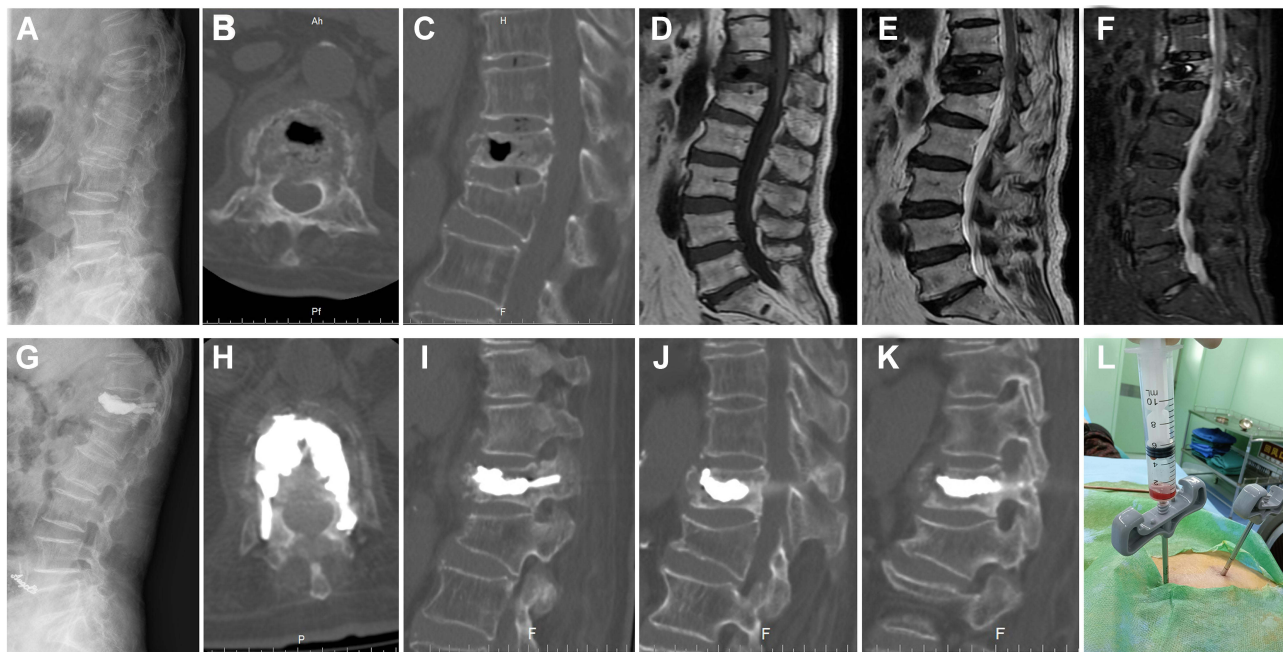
Treatment of Kummell's disease via three-column enhanced PVP. A female aged 85 years complained of "low back pain and discomfort for 2 months". (A) The preoperative lateral X-ray suggested a reduction in the height of the T12 vertebral body. (B and C) Preoperative CT revealed dehiscence of the anterior middle region of vertebra T12 and formation of a vacuum fissure within the vertebra. (D–F) Preoperative MRI confirmed that the T12 vertebral body was a fresh fracture. Also, the vacuum fissure in the vertebral body evidenced a fluid signal. (G) The patient underwent three-column, enhanced PVP. An X-ray taken on the first day after surgery revealed that the bone cement was evenly distributed in the vertebral body and the pedicle. (H) A postoperative plain cross-sectional CT scan showed that the bone cement was evenly distributed in the vertebral body and bilateral pedicle, without leakage into the vertebral canal. (I–K) A postoperative plain sagittal CT scan showed that the bone cement was evenly distributed in the vertebral body and bilateral pedicle. (L) A light-red clear liquid was drawn from the vertebral fissure during the operation.
